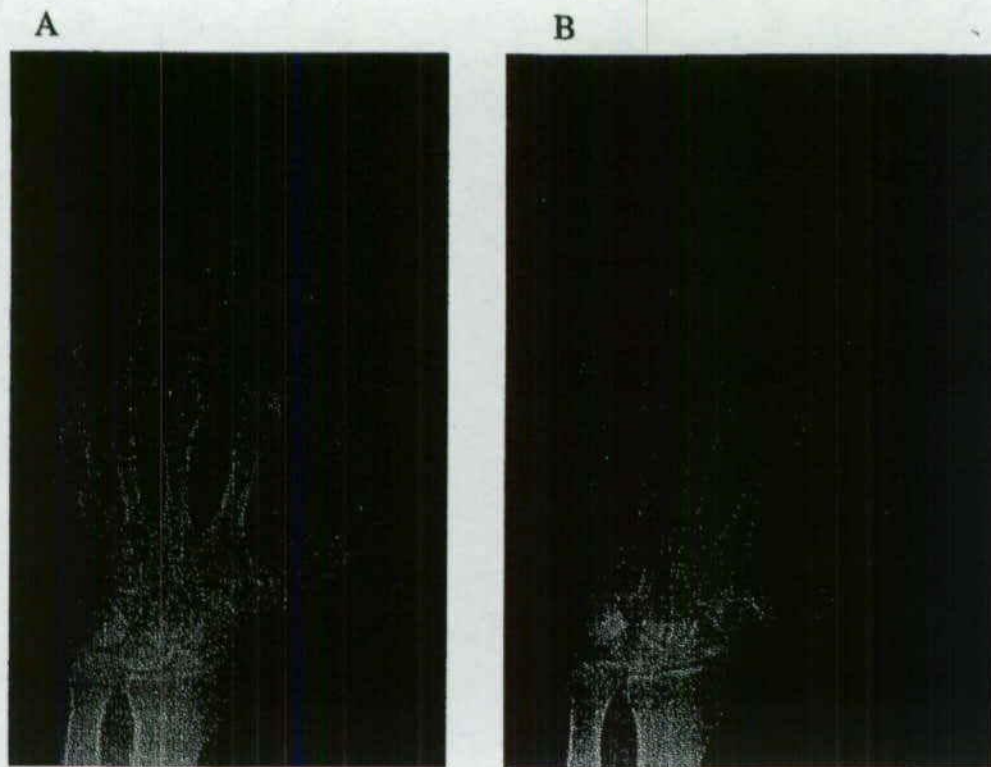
Left hand X-ray examinations before deep brain stimulation of the subthalamic nucleus (STN-DBS) (A) and three years after STN-DBS (B). Although the dislocated distal interphalangeal joint of the thumb did not show improvement due to fixed contracture, the interdigital spaces were clearly expanded after STN-DBS.
